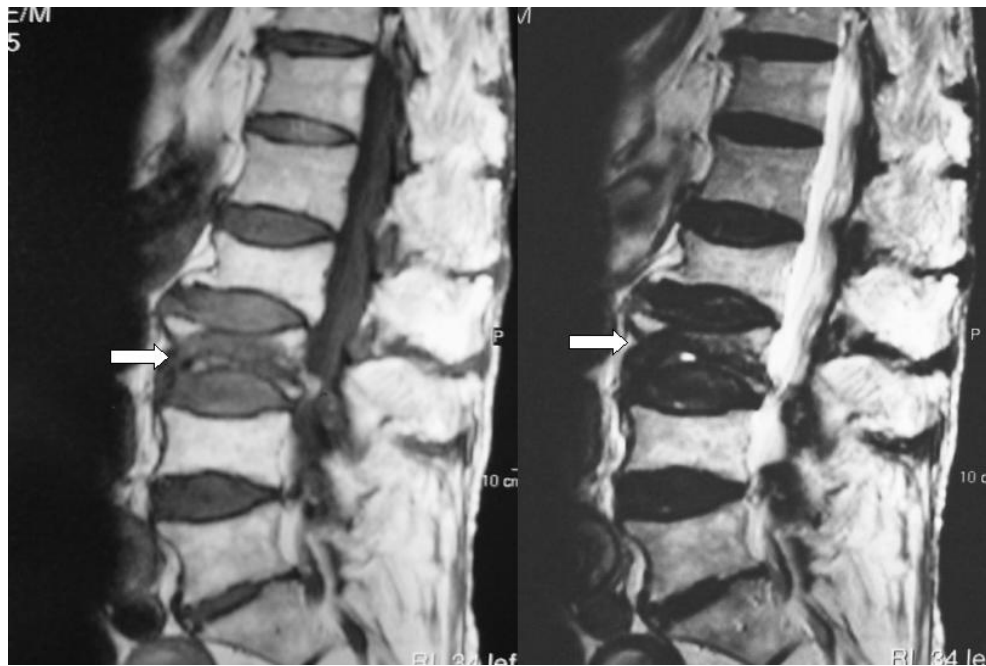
Initial MRI of the lumbar spine revealed reduction of the height of L-2~L-4 and a homogenous decreased signal lesion (arrows) in the vertebrae body of L-3 on both T1-weighted (left panel) and T2-weighted images (right panel).
